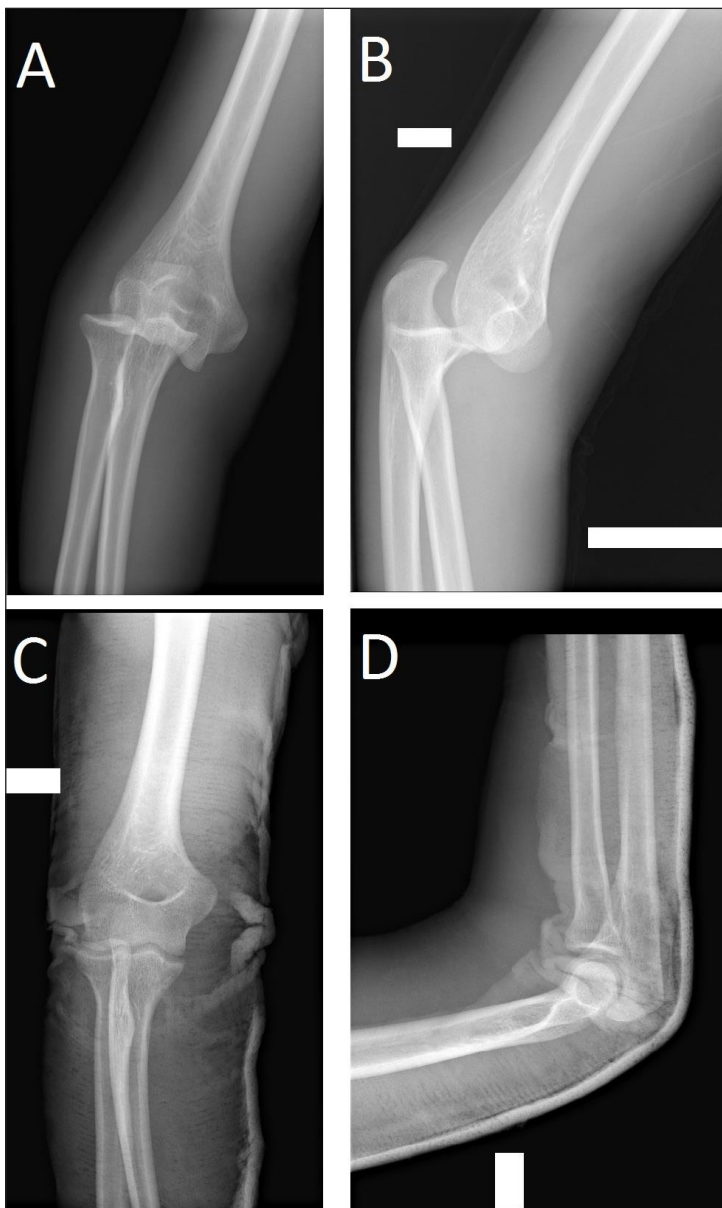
A–B – plain elbow radiographs demonstrate a posterolateral dislocation of the elbow. C–D – a radiographic view after closed reduction – joint congruence is restored, no signs of bony lesions
